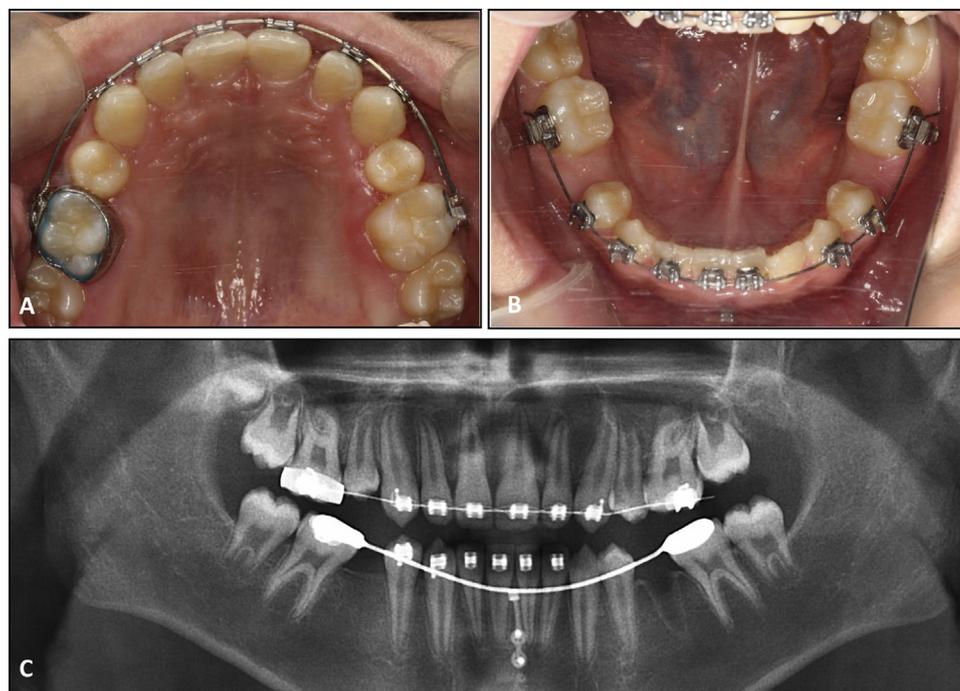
A, B, Intraoral view 4 months after left-side transplantation (12 years 6 months of age). C, Panoramic radiograph immediately after second transplantation (12 years 3 months of age).
